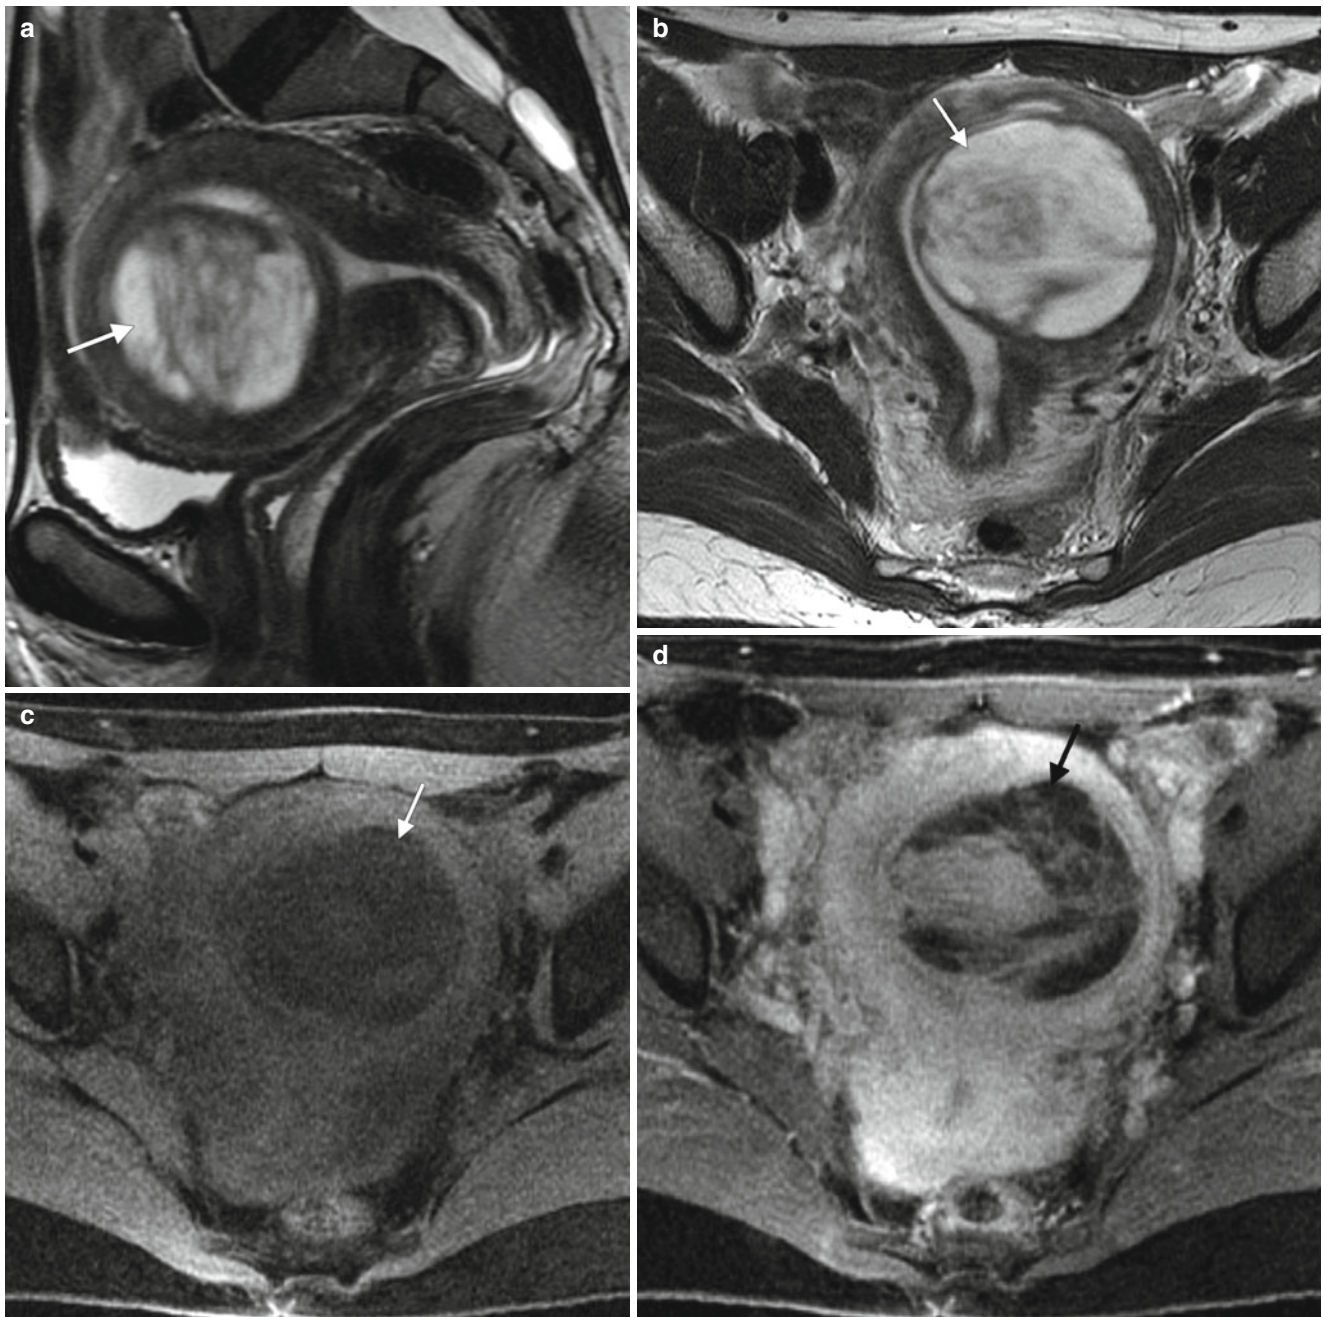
The appearance of uterine leiomyomas is variable. These images show a 44-year-old woman with worsening menometrorrhagia over 3 years. Sagittal (a) and axial (b) T2-weighted MR images and axial fat-suppressed T1-weighted images before intravenous gadolinium
